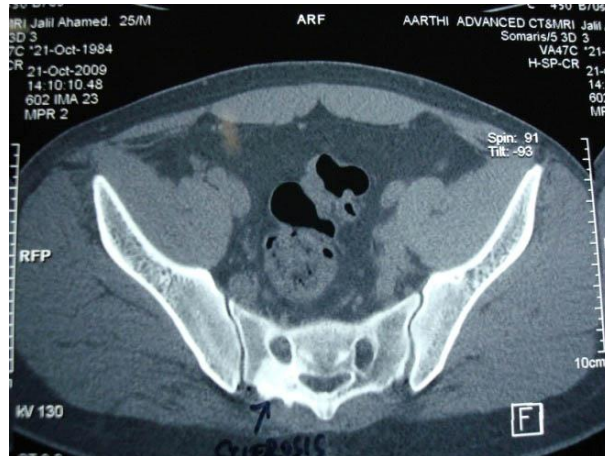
CT showing region of sclerosis in second sacral arch .
